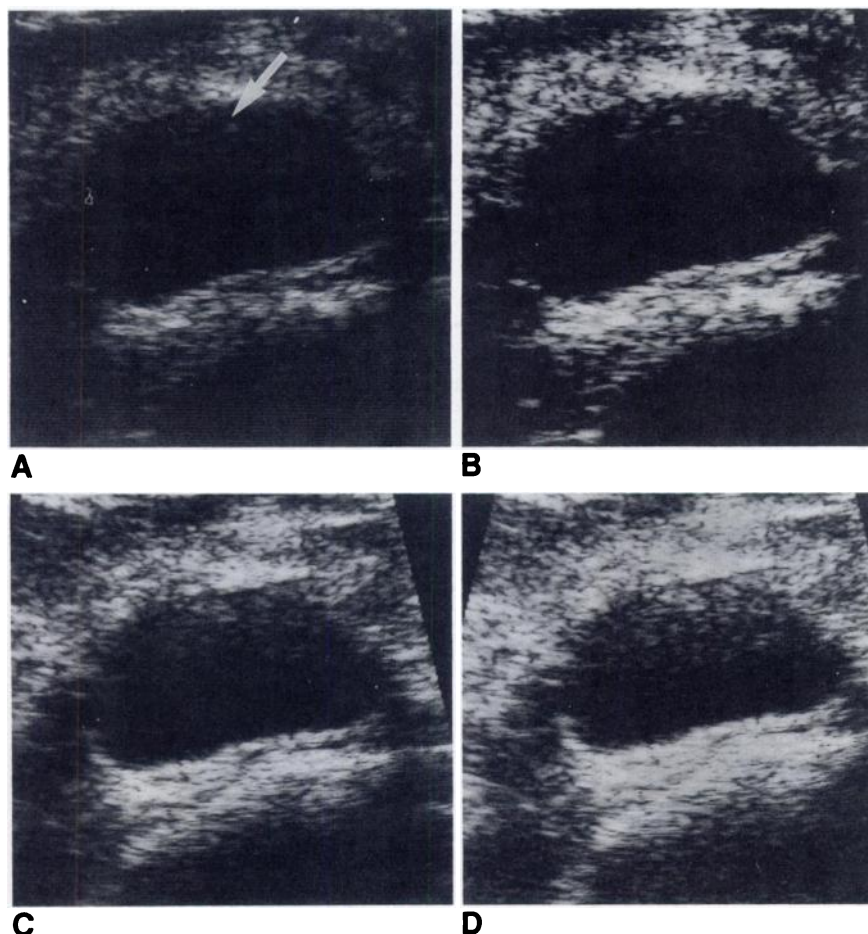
Sonograms of cyst. Effects of changing sonographic power and gray scale.
